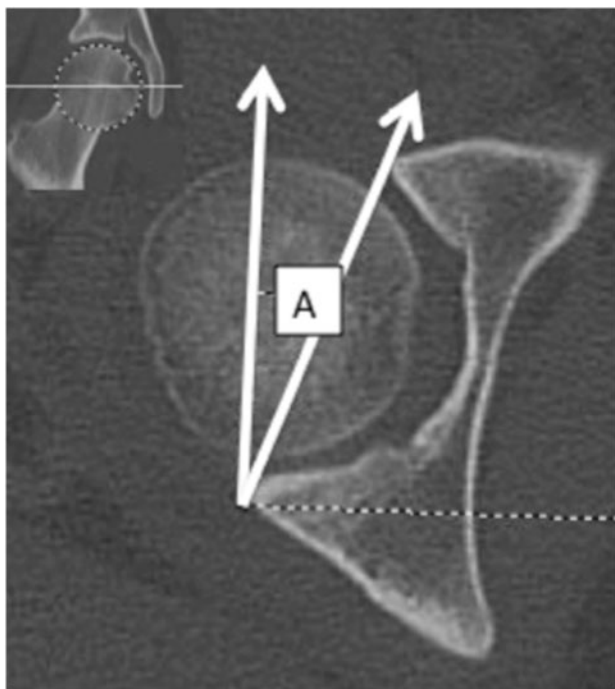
CT acetabular version measurement technique. The axial cut extending through the center of a best-fit circle on the central coronal reconstructed cut (inset image) was used to calculate the equatorial acetabular version. The angle between a line drawn tangent to the anterior and posterior walls of the acetabulum and a true sagittal line was the CT acetabular equatorial version.
